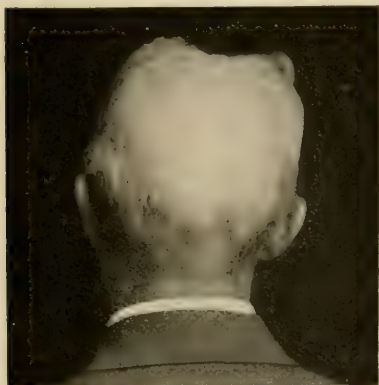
Case of alopecia produced in effort to make antero-posterior radiograph of the antra.
